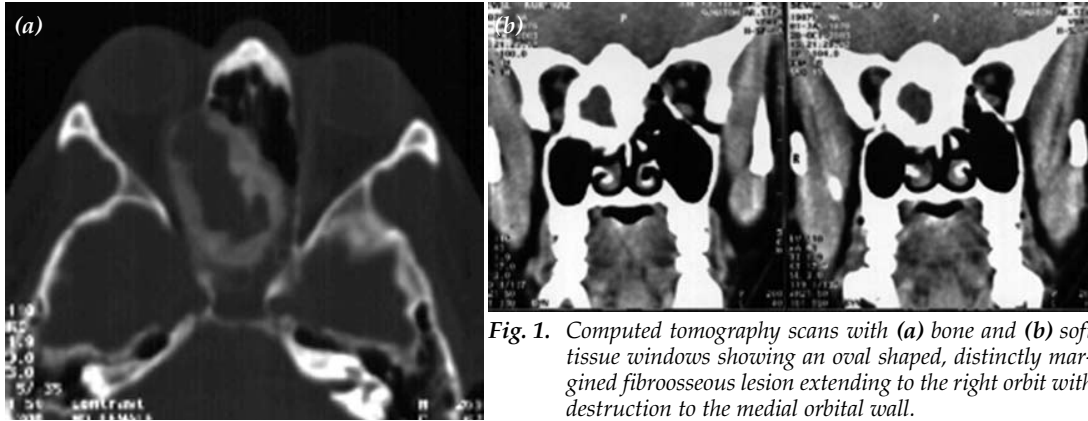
Computed tomography scans with (a) bone and (b) soft tissue windows showing an oval shaped, distinctly margined fibroosseous lesion extending to the right orbit with destruction to the medial orbital wall.
